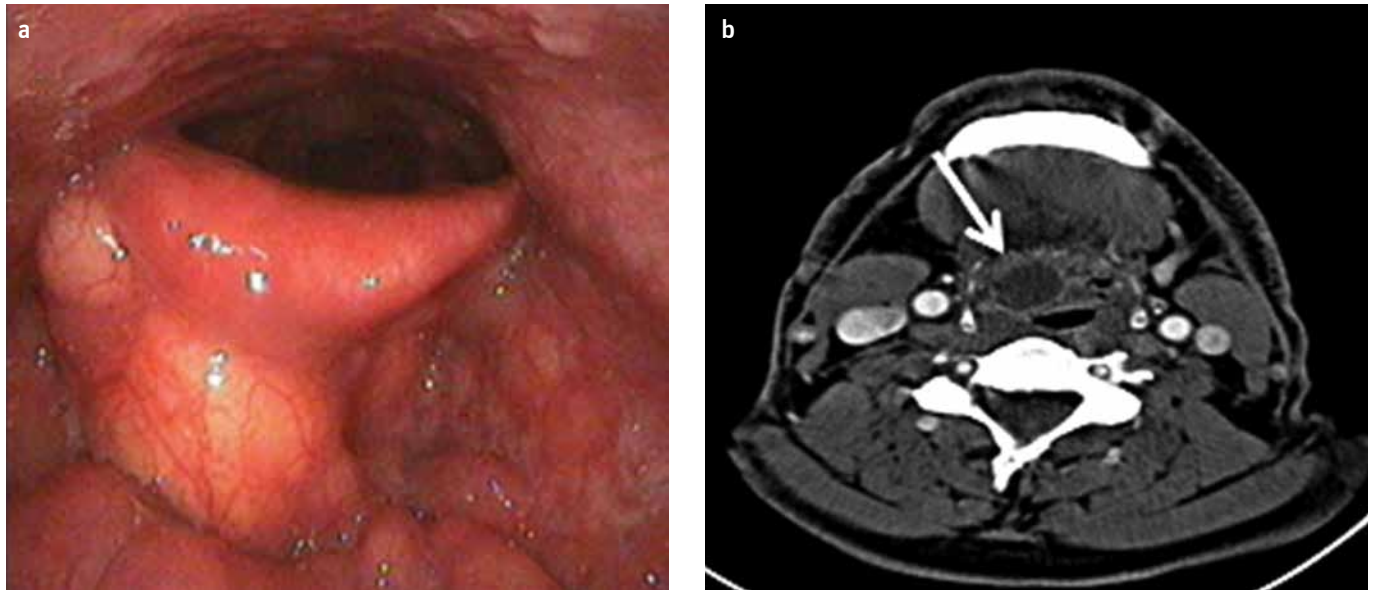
a, b. Fiberoptic endoscopic view of the epiglottic cyst (a) and the computed tomographic scan of the neck demonstrating the same cyst (white arrow) (b).
